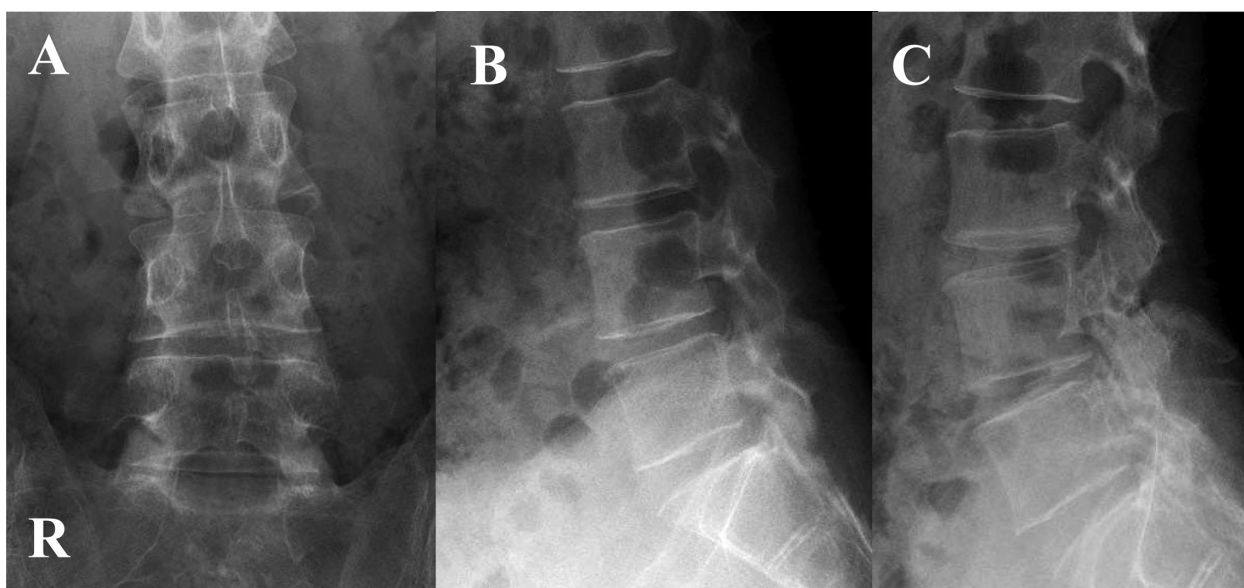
X-ray films of the lumbar spine. A) Anteroposterior (A-P) view. Slight scoliosis can be seen. B) Lateral view with flexion. C) Lateral view with extension. These X-ray films show no instability, and the disc height and alignment are normal.
